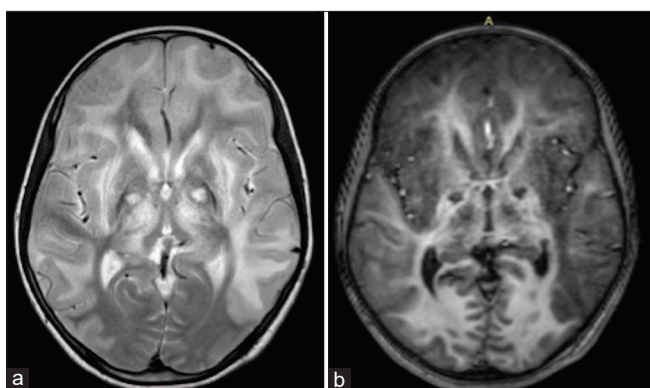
Magnetic resonance imaging of the brain in the patient (a) axial T2-weighted and (b) T1-weighted images show involvement of bilateral basal ganglia, external capsules, thalami, and subcortical white matter
